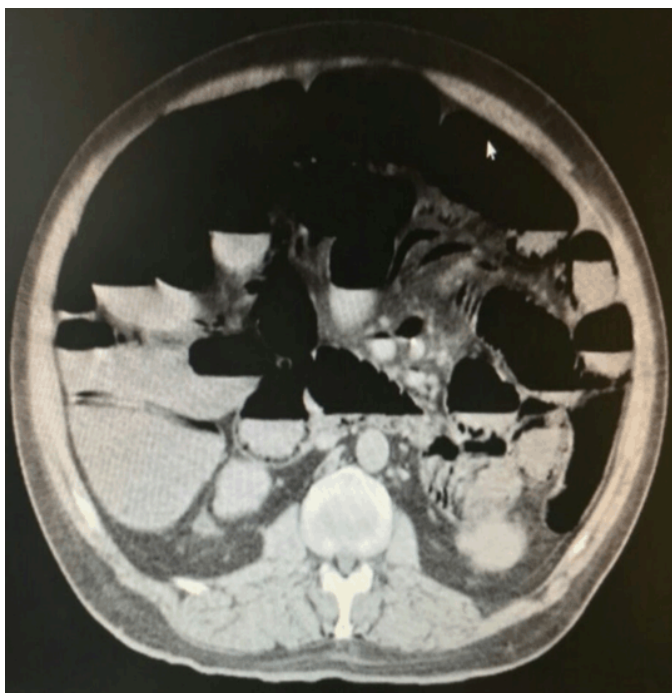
Computed tomography scan of the abdomen showing multiple air fluid levels with evidence of pneumatosis intestinalis at the level of small bowel.
